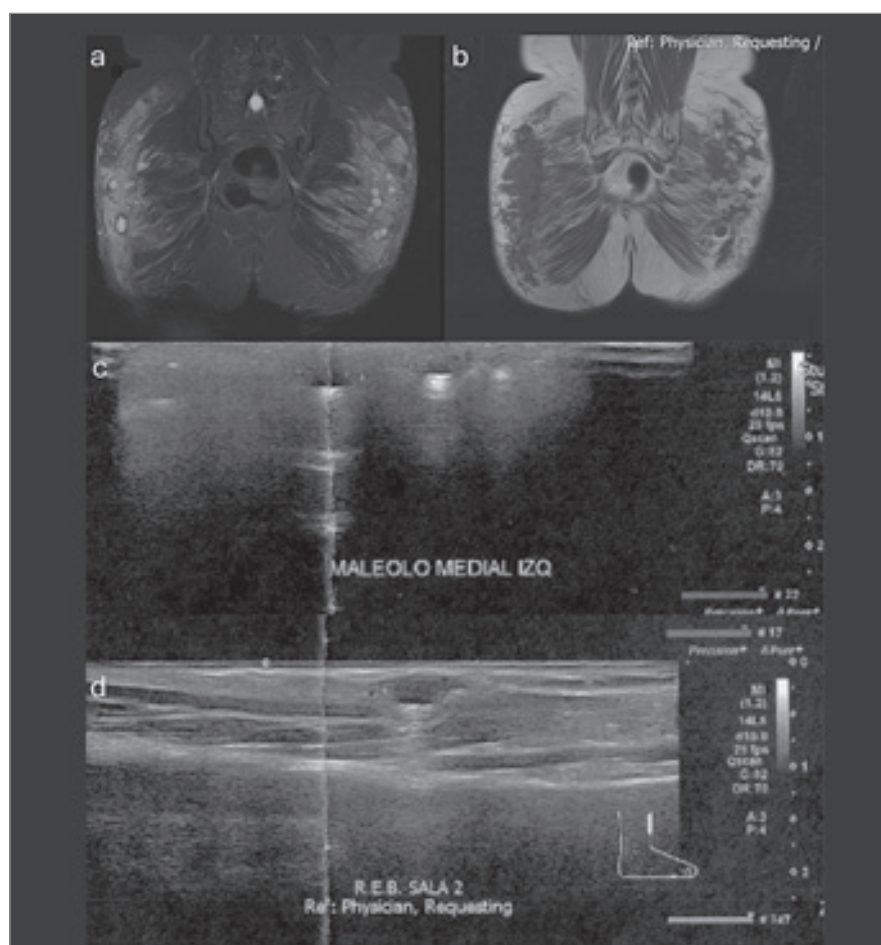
MRI of the pelvis and ultrasound of the ankle.
